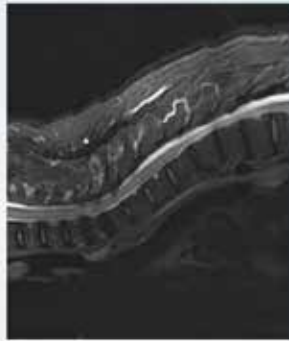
Sagittal view of CT Thoracic Spine
